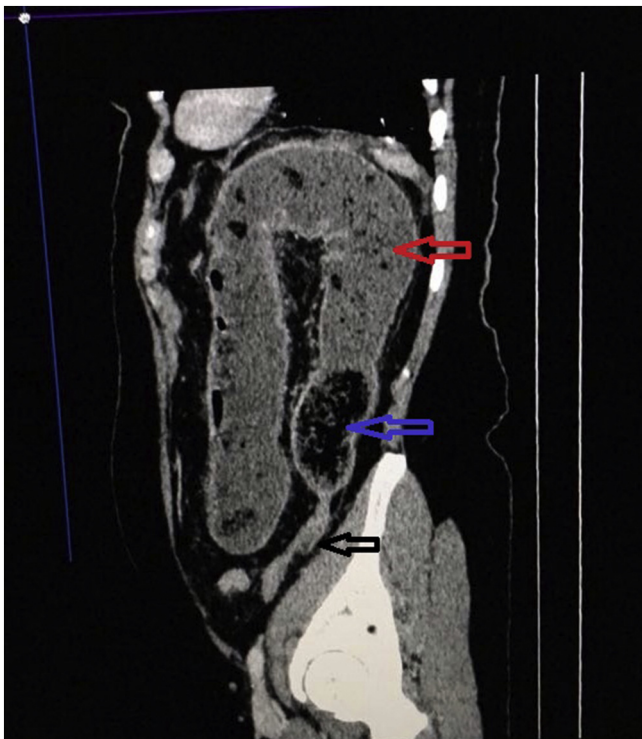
CT scan of abdomen and pelvis with intravenous contrast (coronal view), the blue arrow indication the mottled gas appearance of the phytobezoar at descending colon, the red arrow indication dilated proximal colon.
